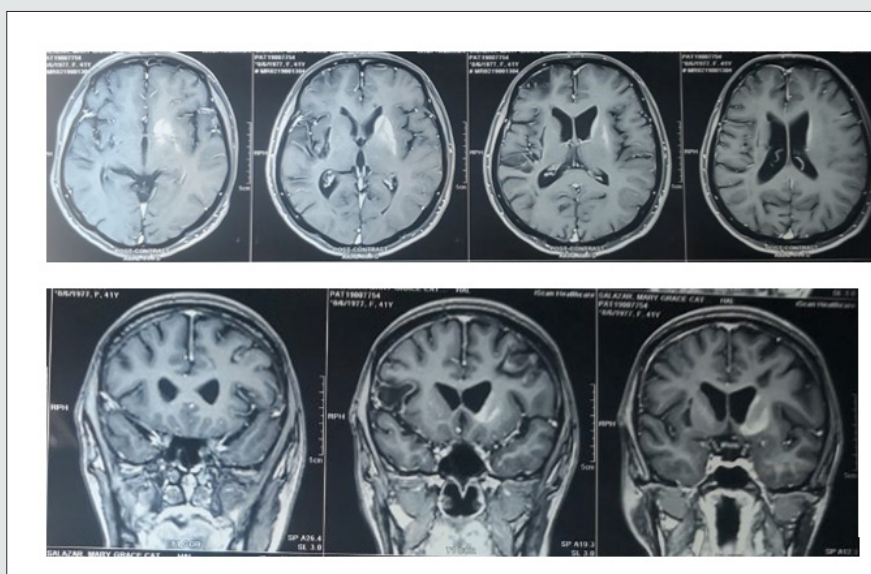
Cranial MRI with contrast T1 post-contrast sequence.
